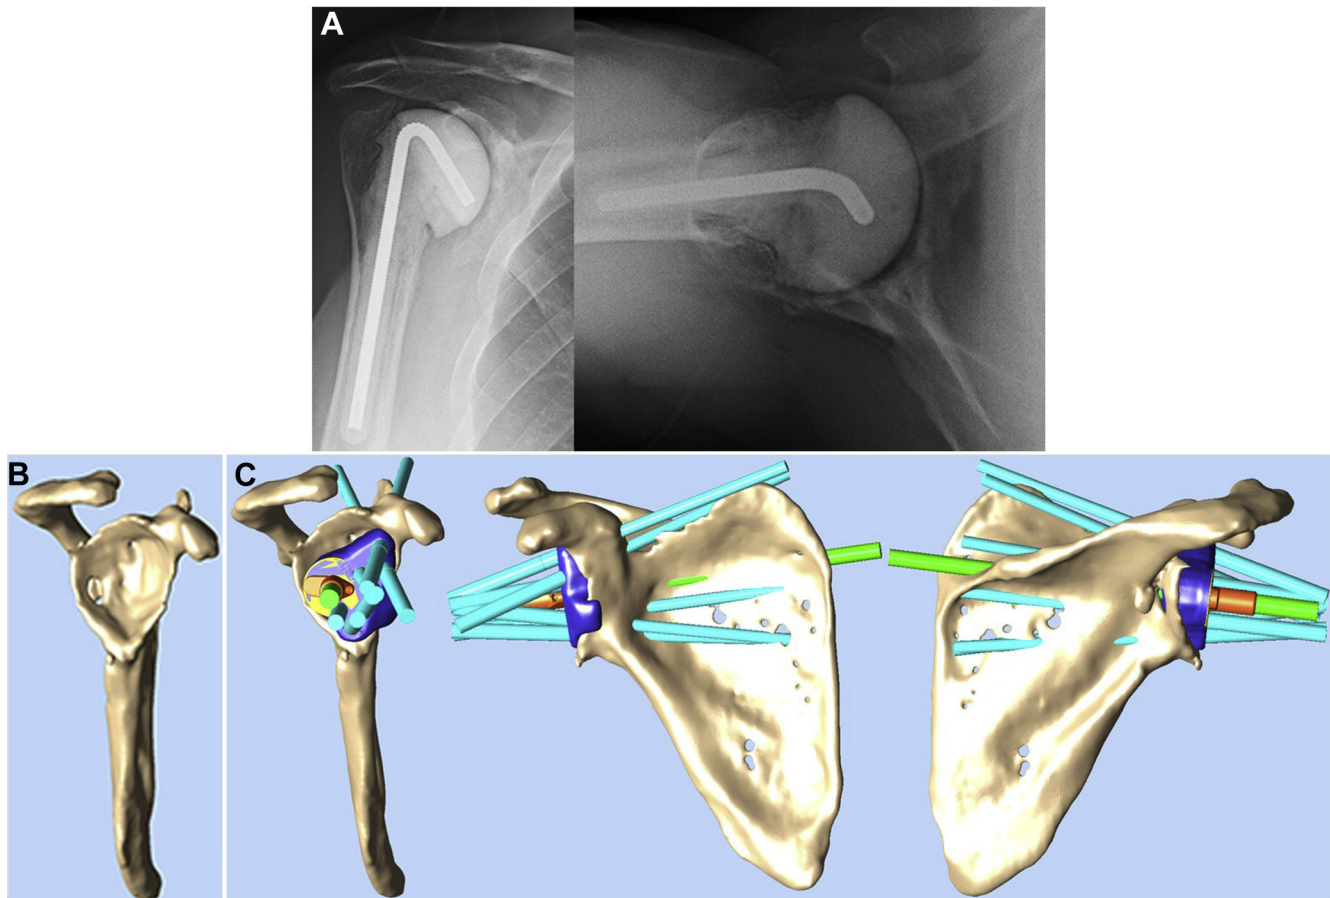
(A) Preoperative anteroposterior and axillary radiographs of patient 2 showing antibiotic spacer placement and severe glenoid bone deficiency. (B) Preoperative computed tomography–based 3-dimensional reconstruction showing severe combined central and posterior bone loss. (C) Preoperative Comprehensive Vault Reconstruction System (VRS) plan showing the implant, central and peripheral screw trajectories, planned custom boss, and built-in anterior lip to assist with positioning and orientation. The inferior glenoid osteophyte was removed to prevent scapular notching once the VRS was securely implanted.
